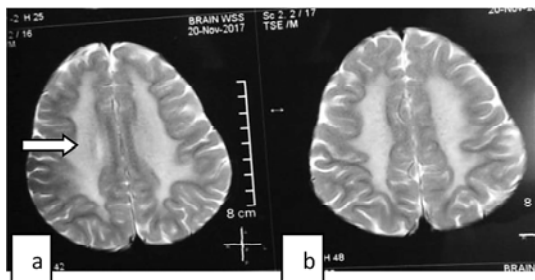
Metachromatic leucodystrophy Axial T2 MR image showing bilateral symmetrical periventricular white matter hyperintensity. b. Tigroid pattern.
